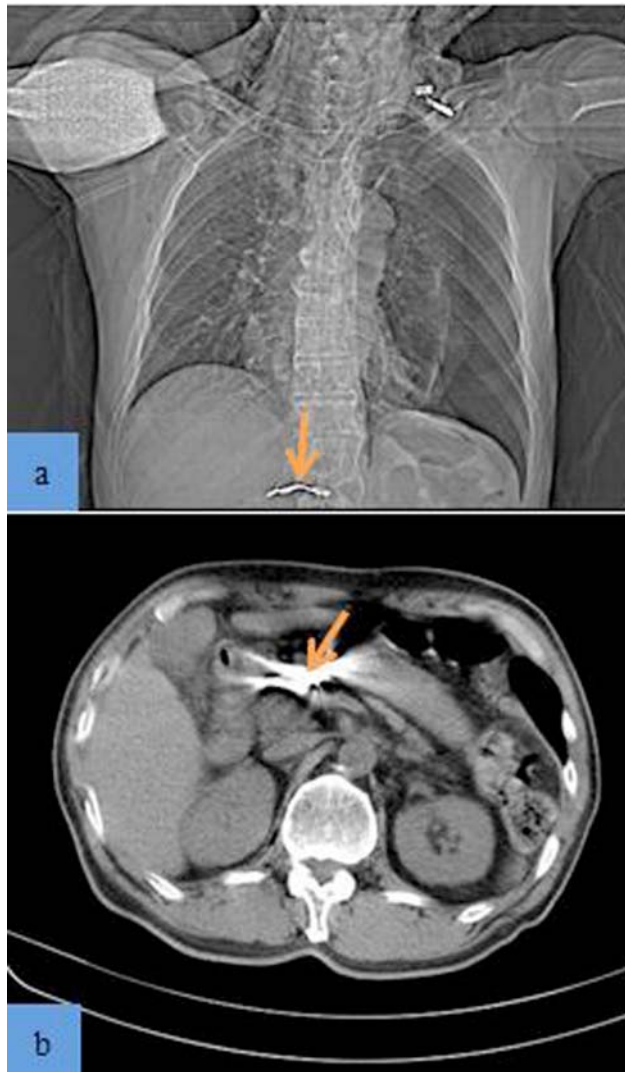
CT scans (a and b) showed the dentures in the gastric cavity.
